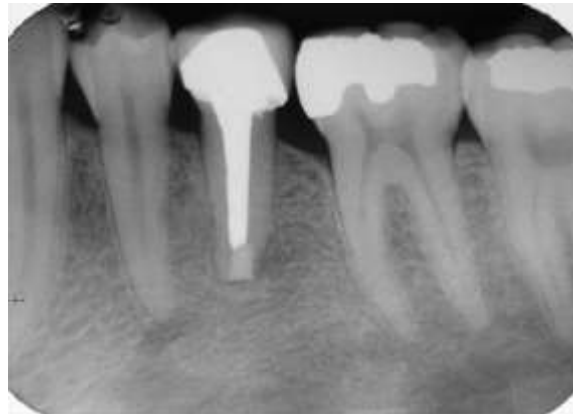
15 months postoperative radiograph reveals complete osseous healing of the peri-apical radiolucency.
